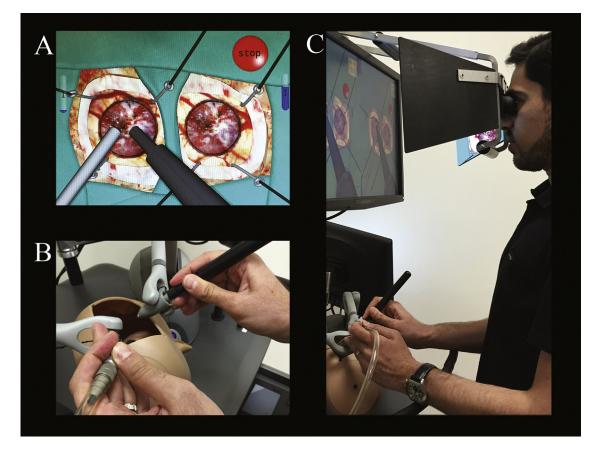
(A) Operator view of 2 of the 3 tumors to be resected with a sucker in nondominant hand and ultrasonic aspirator in dominant hand. (B) Haptic instruments used by participants. (C) Model performing task.
